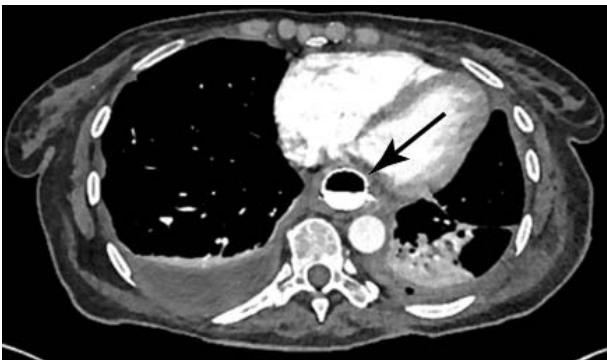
CT with intravenous and oral contrast after stent placement
